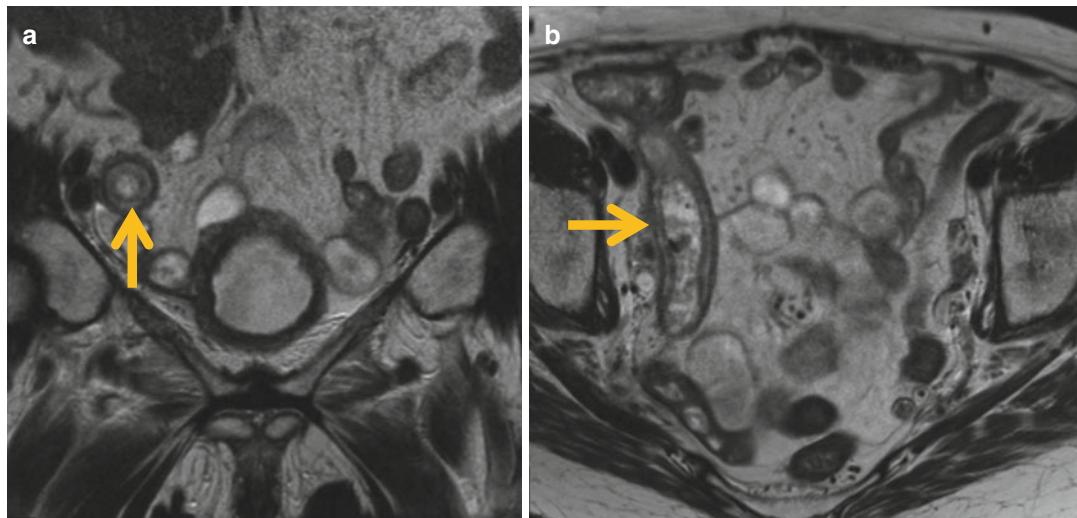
Radiation-related changes to bladder and small bowel loop. (a) Axial and (b) coronal T2-weighted images through the pelvis in a patient who received pelvic radiotherapy for bladder cancer. The bladder is small volume
